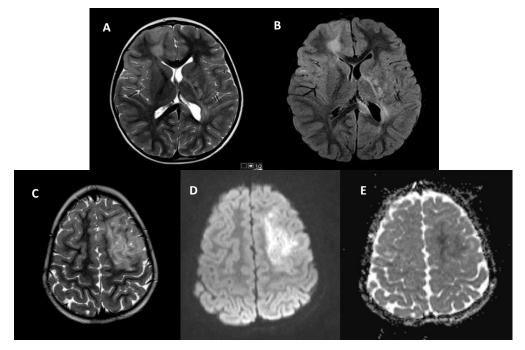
In the axial T2WI (A) and FLAIR (B) sections, hyperintense lesions are observed at the level of the subcortical and periventricular frontal and frontobasal white matter; in the corpus callosum on the left, and striato-capsular on the left. In the axial T2WI sections (C) we can observe an area of hypersignal with restriction to diffusion which translates into a hypersignal on DWI (D) and hyposignal on ACD (E).
